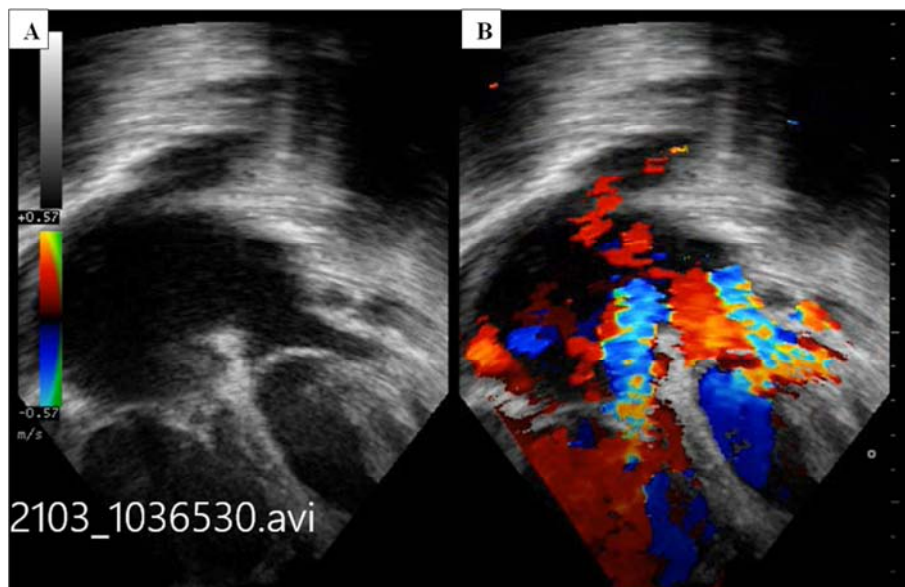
(A) 2-dimensional Echocardiography, apical 4 chamber view showing OS ASD, enlarge right heart chambers (B) Colour mapping demonstrating shunt across, MR and TR jets.
